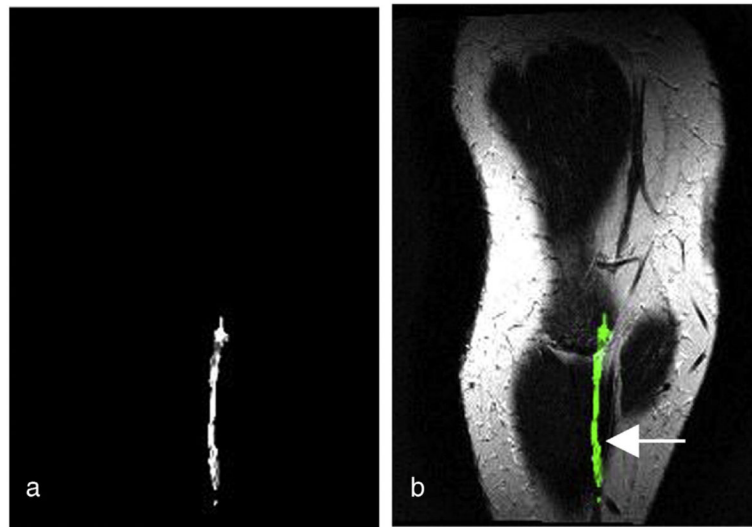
(a) An FA map from 15 gradient direction DTI. (b) The FA map (green) co-registered with the anatomical T₂-weighted MRI of the same subject in the oblique coronal view. The figures demonstrate the localization of the anisotropic diffusion along the anatomically defined sural nerve (arrow) in MRI.
